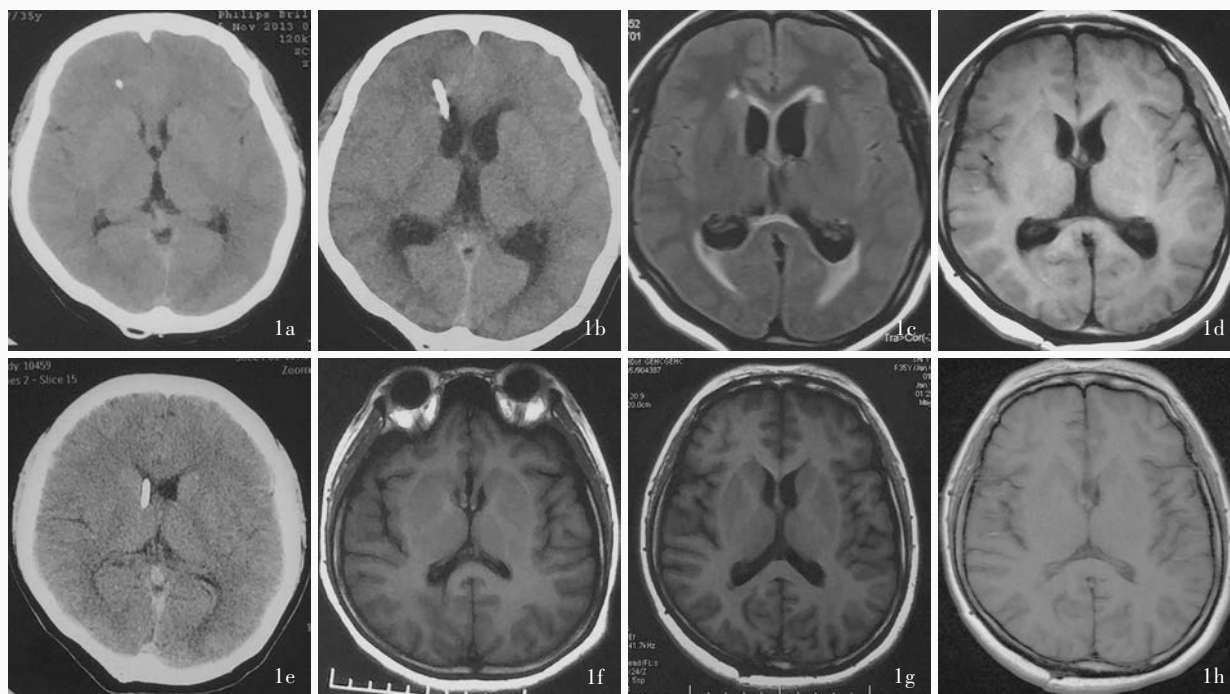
头部影像学检查所见 1a 横断面 CT(2013 年 11 月 5 日)显示双侧侧脑室明显缩小 1b 横断面 CT(2013 年 12 月 24 日)显示双侧侧脑室扩大 1c 横断面 FLAIR 成像(2014 年 1 月 13 日)显示双侧侧脑室扩大 1d 横断面 T₁WI(2014 年 5 月 20 日)显示双侧侧脑室扩大 1e 横断面 CT(2014 年 11 月 27 日)显示双侧侧脑室明显缩小 1f 横断面 T₁WI(2014 年 12 月 17 日)显示双侧侧脑室较图 1e 扩大 1g 横断面 T₁WI(2015 年 1 月 21 日)显示双侧侧脑室较图 1f 扩大 1h 横断面 T₁WI(2015 年 3 月 5 日)显示双侧侧脑室较图 1g 缩小
